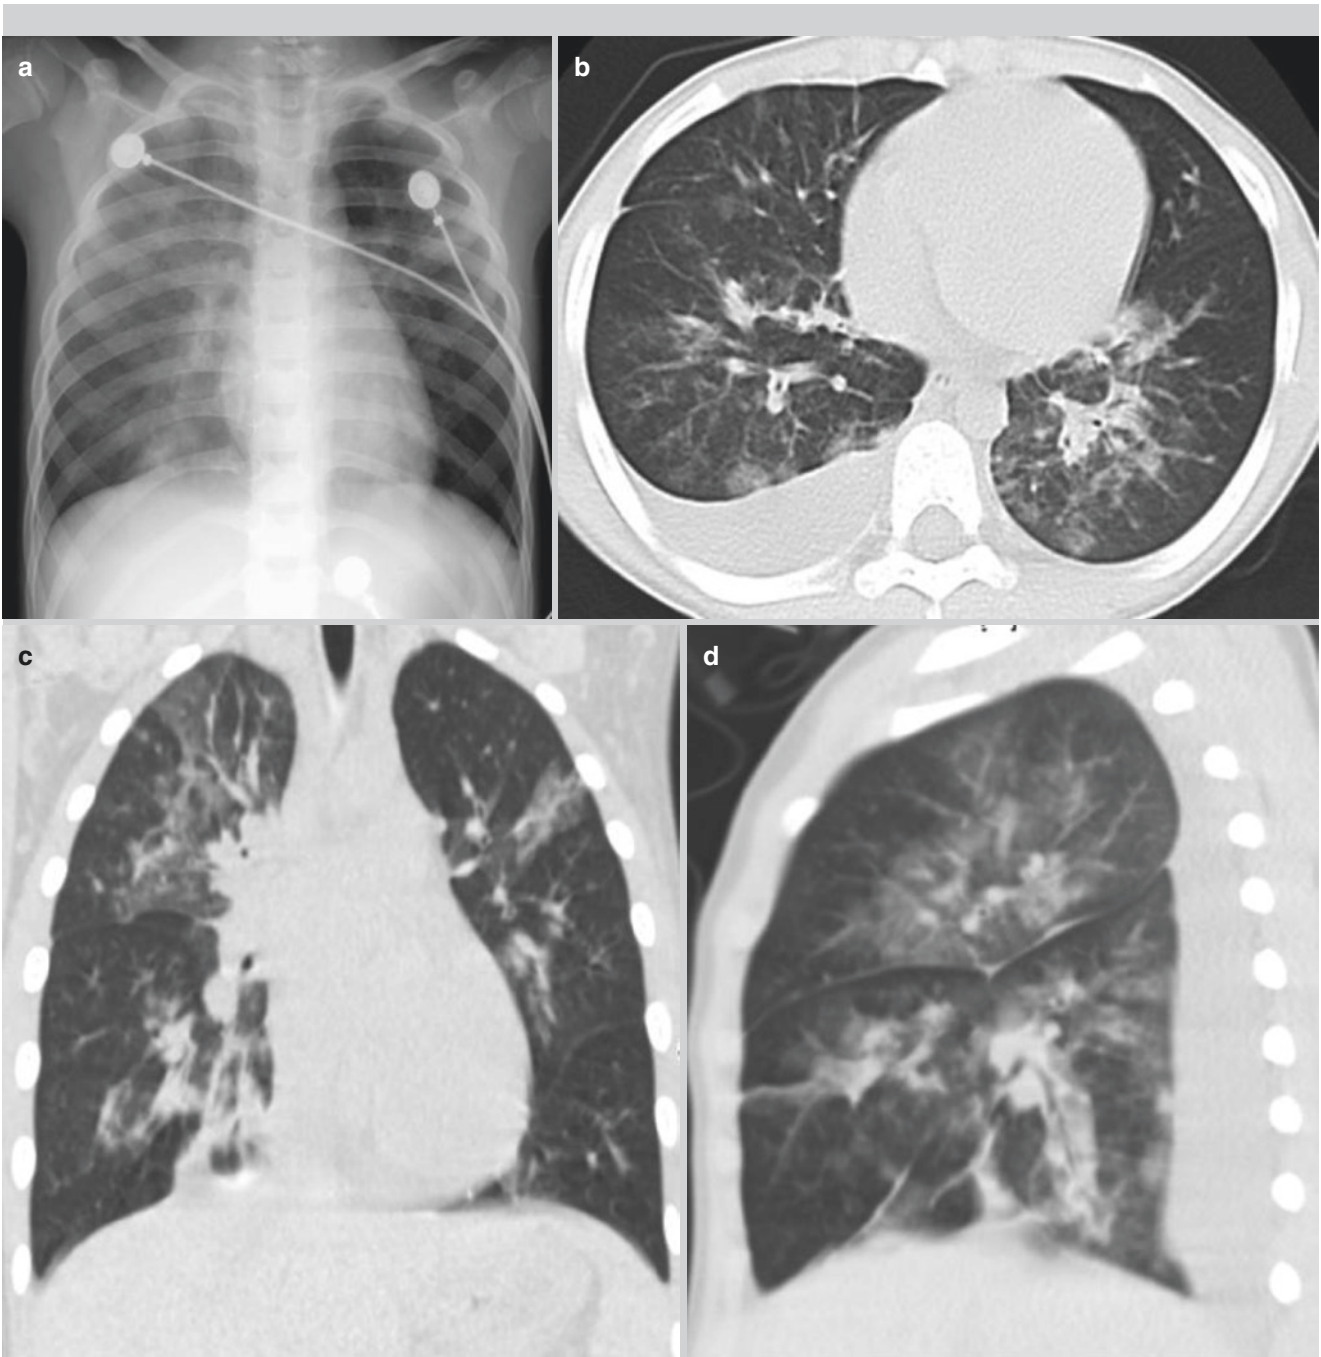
Chest X-ray showed thickened lung markings, decreased transparency of the right lung field, sporadic flakes of poorly defined opacities in both lung fields (a). CT scan demonstrated ground glass
